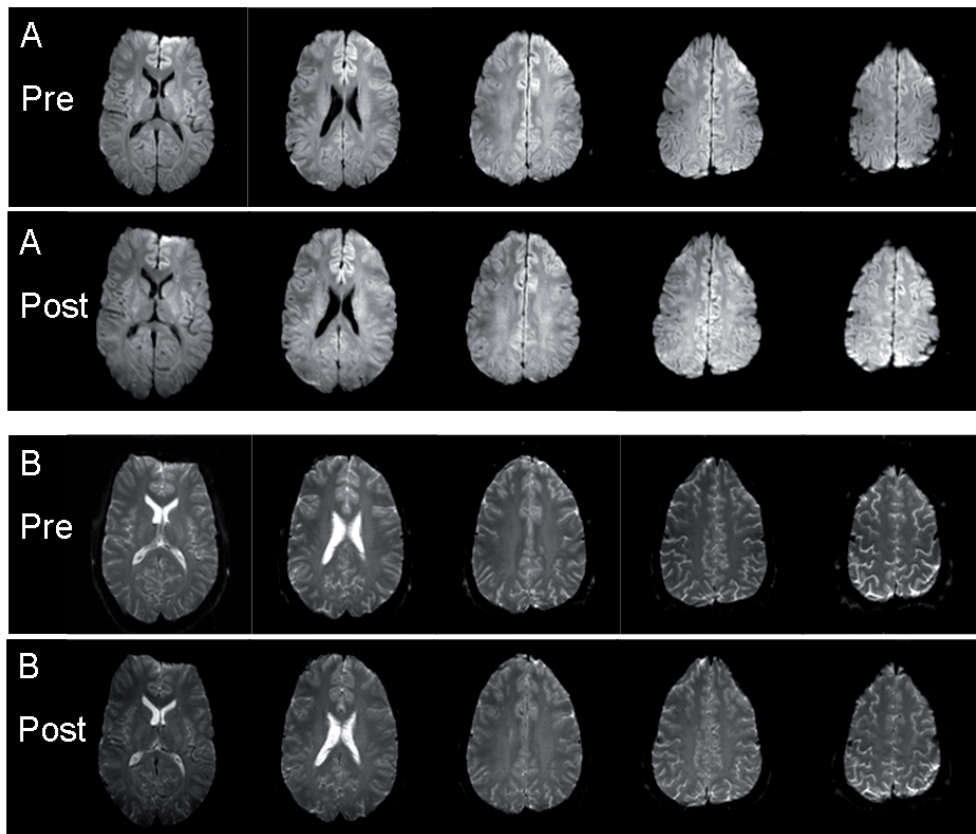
Axial diffusion-weighted (A) and T2-weighted (B) MR images obtained at baseline (upper rows) and after 6-hours exposure to hypoxia (lower rows) from subject 4 who suffered from severe acute mountain sickness. There is no evidence for the development of cerebral edema at visual inspection.
